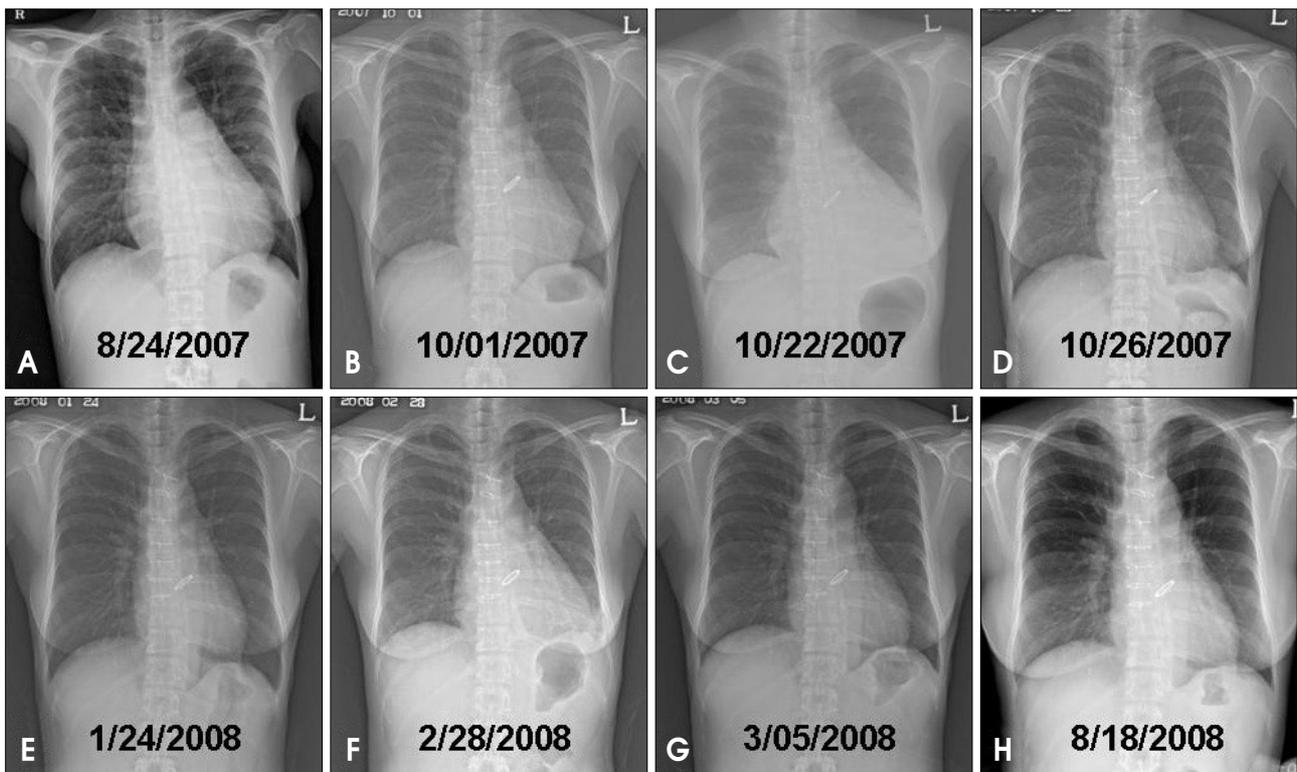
A series of chest X-ray. Preoperative chest X-ray showed moderate cardiomegaly with increased pulmonary vascularity (A). Cardiomegaly and pulmonary congestion after operation was resolved (B). In 8 weeks after surgery, chest X-ray showed aggravated cardiomegaly compared with previous one (C). Under the diagnosis of postoperative effusive-constrictive pericarditis, patient was treated with prednisolone and ibuprofen for 7 weeks. Chest X-ray showed normalized heart size within 1 week (D) and after treatment (E). In 3 months after steroid discontinuation, chest X-ray revealed cardiomegaly again (F). The patient was suspected as recurrent effusive-constrictive pericarditis potentially associated with steroid discontinuation. Chest X-ray showed normalized heart size within 1 week (G) and in 6 months (H) after re-treatment with steroid.
